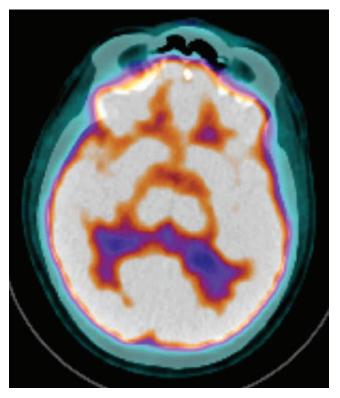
Axial ¹⁸FDG-PET of a normal brain. The PET data is colorized and overlaid on a CT image. Brain areas with higher metabolic activity such as cortex and deep gray nuclei appear bright, and areas with lower metabolic activity such as white matter appear purple.
